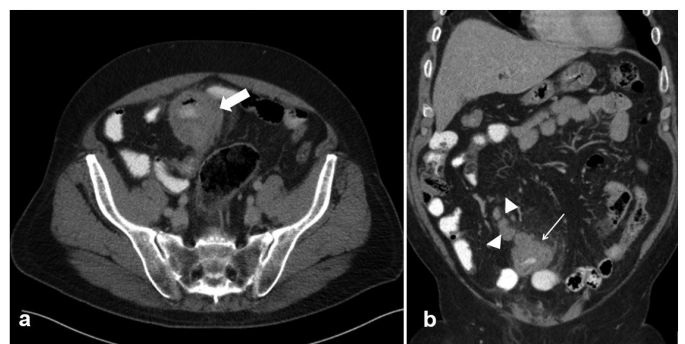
a) Axial computed tomography (CT) image obtained 15 months later shows bulky mass with soft tissue attenuating wall (arrow) representing the adenocarcinoma. b) CT from the same patient/time reveals that a soft tissue mass has grown within the previously affected bowel loop (arrow) with associated infiltrative changes in the local small bowel mesentery. Multiple lymph nodes have also appeared (arrowheads)
